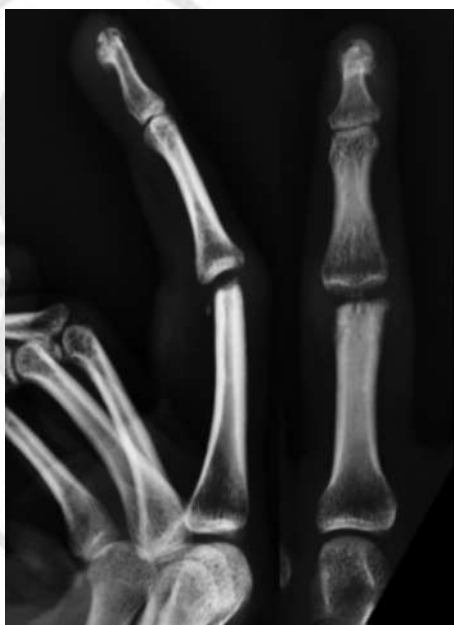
Check radiographs revealed the neck cut in the proximal phalanx to be sloping ulnar wards.
